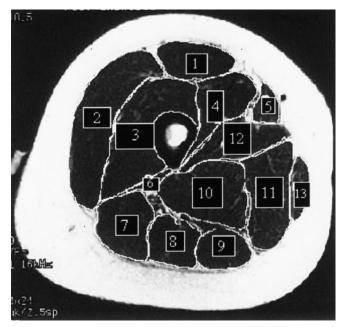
Thigh muscle cross-sectional area determined via magnetic resonance imaging. Individual muscles have been outlined to display boundaries used in the analysis: 1, rectus femoris; 2, vastus lateralis; 3, vastus intermedius; 4, vastus medialis; 5, sartorious; 6, biceps femoris short head; 7, biceps femoris long head; 8, semimembranosis; 9, semitendinosis; 10, adductor magnus; 11, adductor longus; 12, adductor brevis; 13, gracilis.
